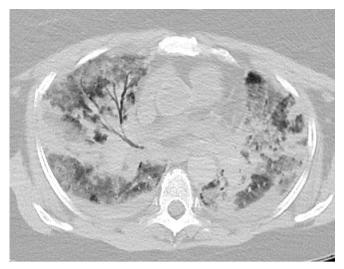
Case 2. Axial CT image of the chest (lung windows) showing bilateral ground-glass opacities and consolidation with bronchial dilatation within involved lung on the right. There are small, bilateral pleural effusions. Case history: A 63 year-old woman was found unresponsive and collapsed at home. She had a history of asthma, lethargy and breathlessness. On external examination she was found to be obese. Additional PMCT findings: Coronary arteries showed minor calcification. The heart appeared normal. There was no acute intracranial pathology. There were CPR-related injuries with bilateral anterior rib fractures, a sternal fracture, and haemorrhage around the liver and spleen. Nose and throat swabs taken at the time of digital autopsy were positive for SARS-CoV-2 RNA. Cause of death: la COVID-19; II Asthma, obesity.
